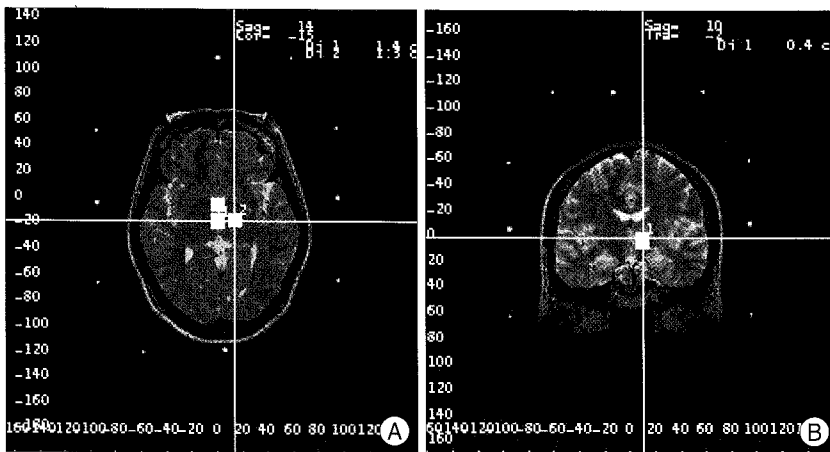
Preoperative magnetic resonance image guided visual targeting of Vo (nucleus ventrooralis) showing (A) axial and (B) coronal T2-weighted images.
